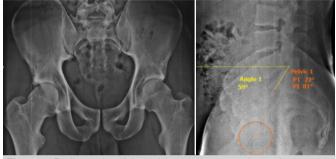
Radiographs of the pelvis showing normal symphysis pubis (AP view, left image) with PI of 81° (lateral view, right image).
